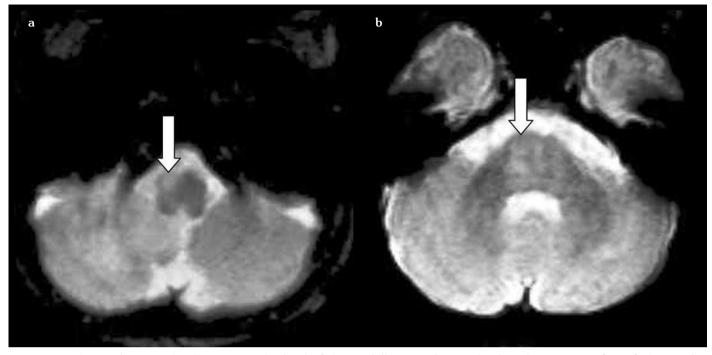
a, b. Axial T2-weighted images at the level of the medulla (a) and pons (b) show hyperintense foci of abnormality (arrows) in the right ventral medulla and in the right side of the pons
